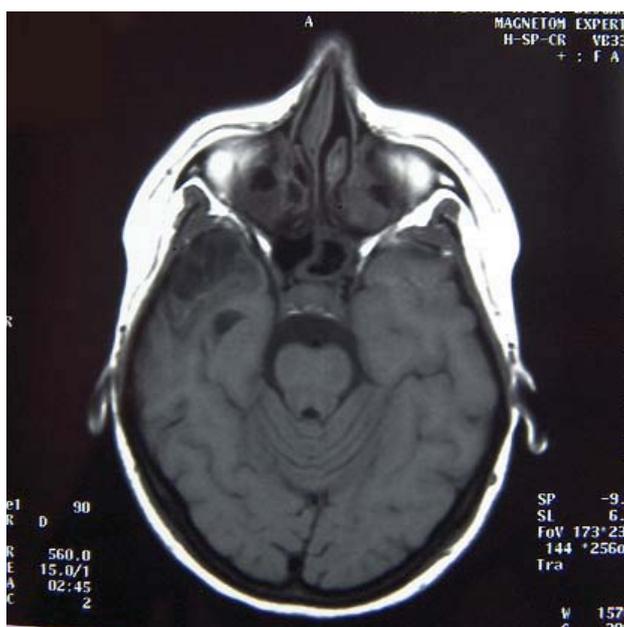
Control endocranial magnetic resonance imaging findings: right temporoparietal hypodense area; and chronic sinusitis (opacification of paranasal cavities).
